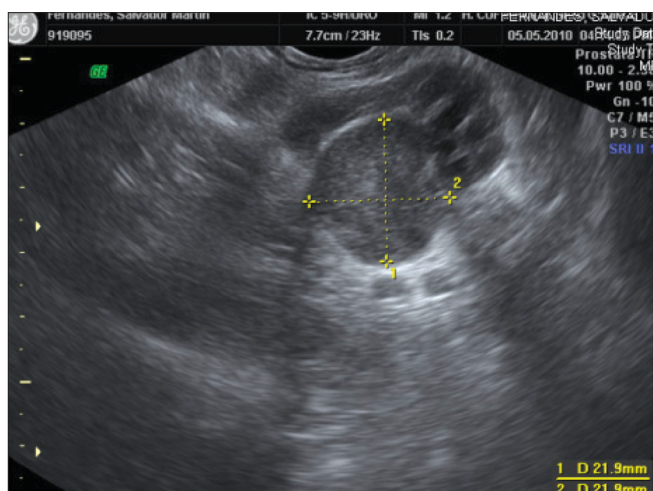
Transrectal ultrasonography presenting a solid mass, measuring 21 x 21 mm on the left seminal vesicle.
